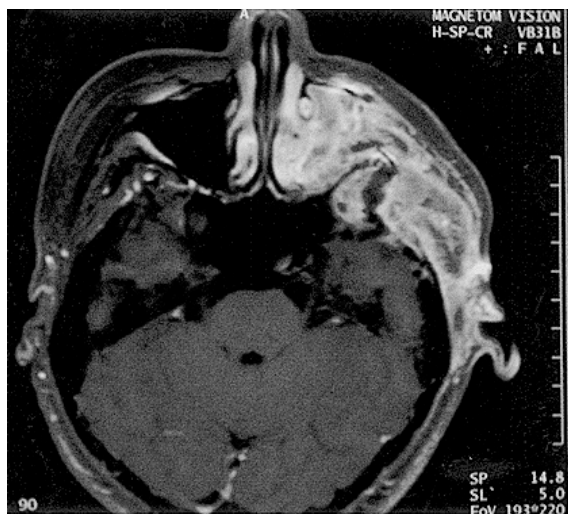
Pre-operative CT scan showing an osteoblastic tumour rising from the sphenoid bone extending to the temporal, fronto-orbital and zygomatic bones and involving the temporalis muscle with sparing of the periorbita and orbital contents and dura covering the frontal and temporal lobes.
